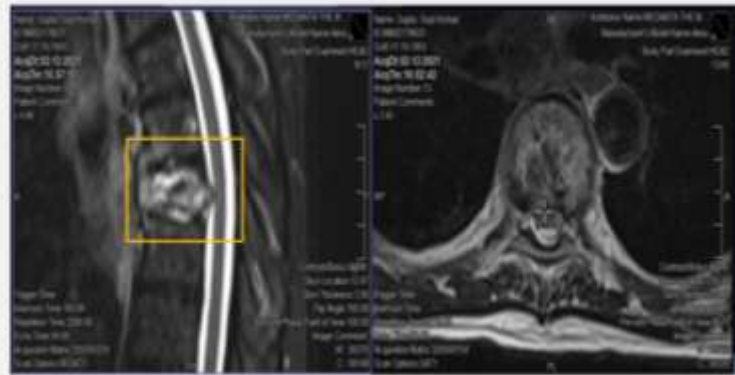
Post separation Surgery MRI showing Bilsky 1c epidural compression
